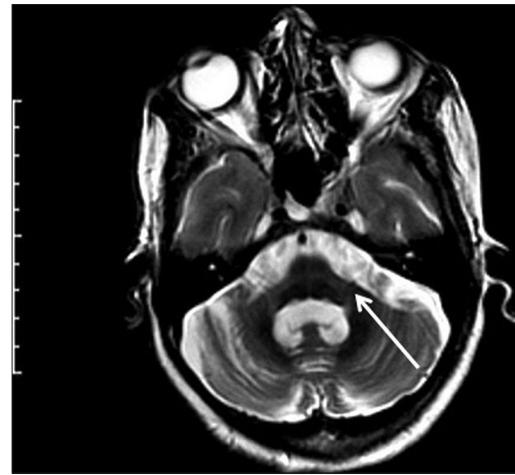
Axial T2-weighted MRI at the level of pons showing cruciform hyperintensity—the "hot cross bun" sign (white arrow)
